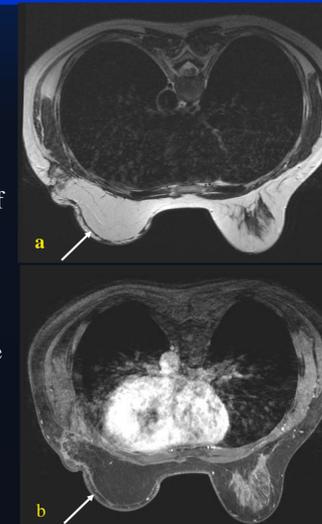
Axial FSE T2W (a) and post-gadolinium MRI (b) of left TRAM flap with de-epithelialized layer of lower abdominal tissue (arrows).
